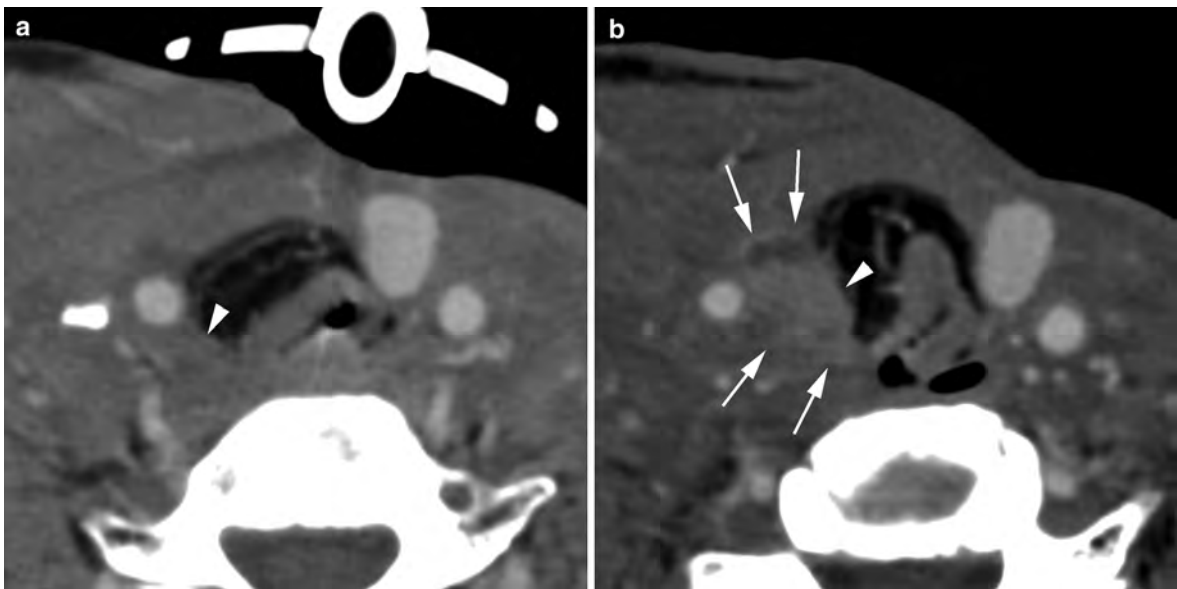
Axial contrast-enhanced CT images of a patient status post total laryngectomy and partial pharyngectomy with pectoralis major flap reformation; imaging was performed immediately post surgery (a) and 3 months later (b); a large recurrent tumor along the lateral margin of the surgical bed (*arrows* in b) is seen 3 months after surgery. Note the changes
